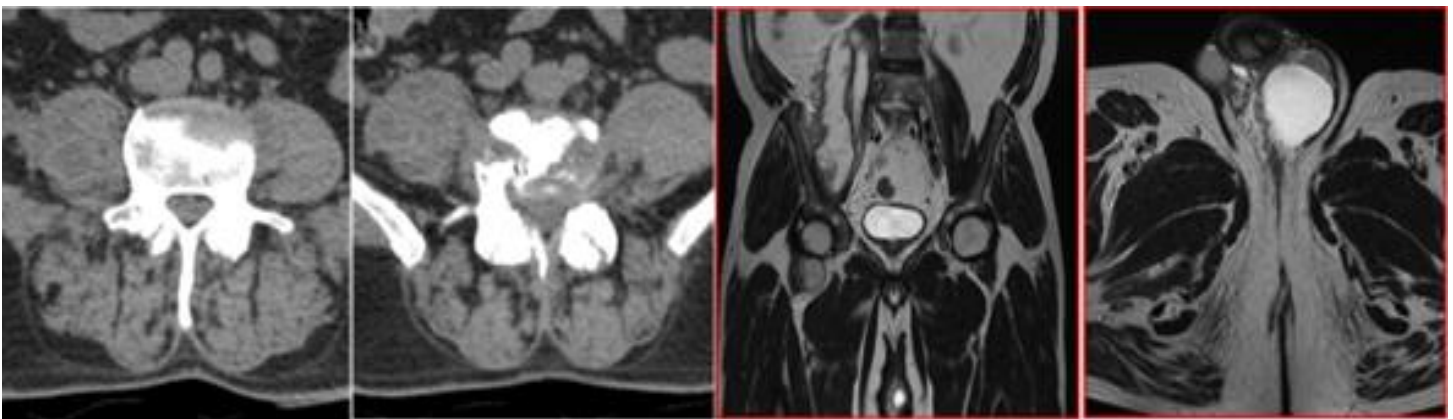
CT Image of lumbar spine showing altered density involving L4 & L5 vertebral bodies with reduced disc height and end plate irregularity at L4-L5 disc level. MRI of lumbosacral plexus showing Large iliopsoas abscess seen from L1 vertebra down to the lesser trochanter extending deep to the right inguinal ligament~ 5.4/6.2/26.8 cm (AP/transverse/CC). Thin internal septations noted in the abscess
